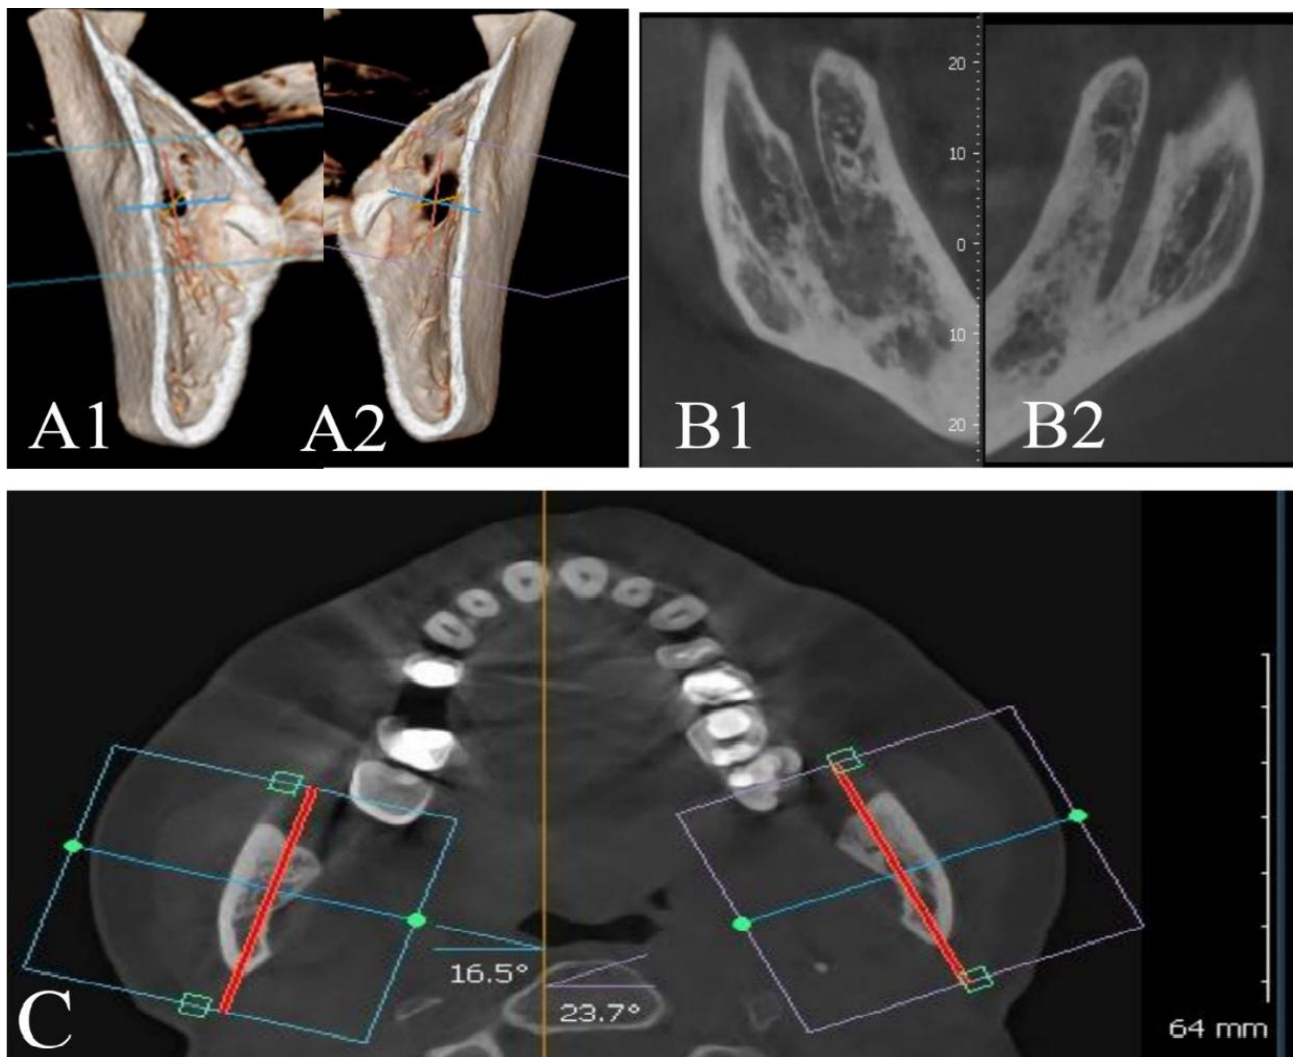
X-ray method of research of the direction of mandibular canal laying, \varnothing° : A1, A2 - coronal section of the mandible; B1, B2 - coronal (smart) section; C - axillary (axial) section of the mandible.
